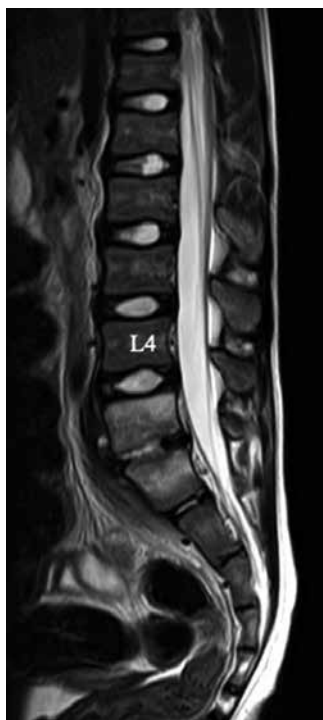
Initial image of the lumbar spine T2-weighted image showing high signal intensity changes in L5, S1 vertebral bodies. Both signal and morphological changes are identified in the L5-S disc space.
